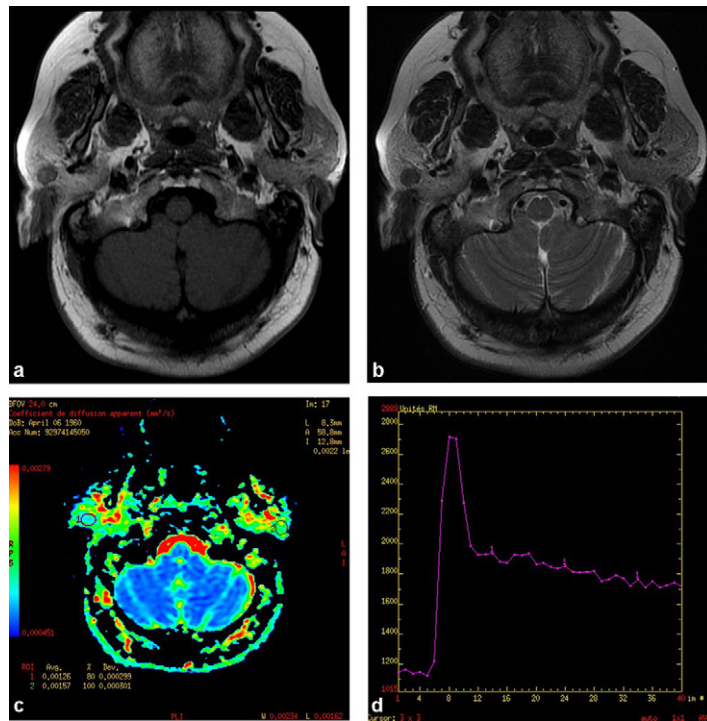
Warthin's tumor. 1 cm tissular lesion of the superficial right parotid: a: T1-weighted axial slice: lesion with high signal intensity on T1-weighted image; b: T2-weighted axial slice: lesion in low signal intensity on T2-weighted image; c: apparent diffusion coefficient map: ACDr = 0.8; d: perfusion curve showing rapid intense uptake with wash-out greater than 30%.
